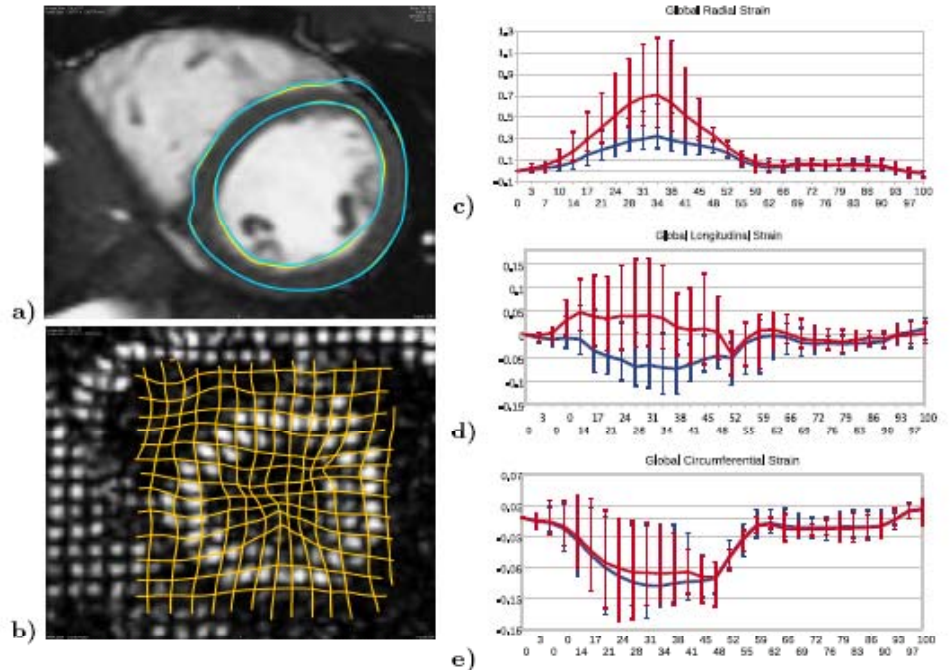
a) End-systole myocardium mask propagated back to the end-diastole image using DD (in yellow) and PCD (in blue). Both algorithms provide similar registration performances. b) Tagged-MRI at end-systole and tag grid deformed by the cine-MRI transformation estimated using PCD. c-e) Global strain with maximum and minimum zone values. Time is normalised in %.
